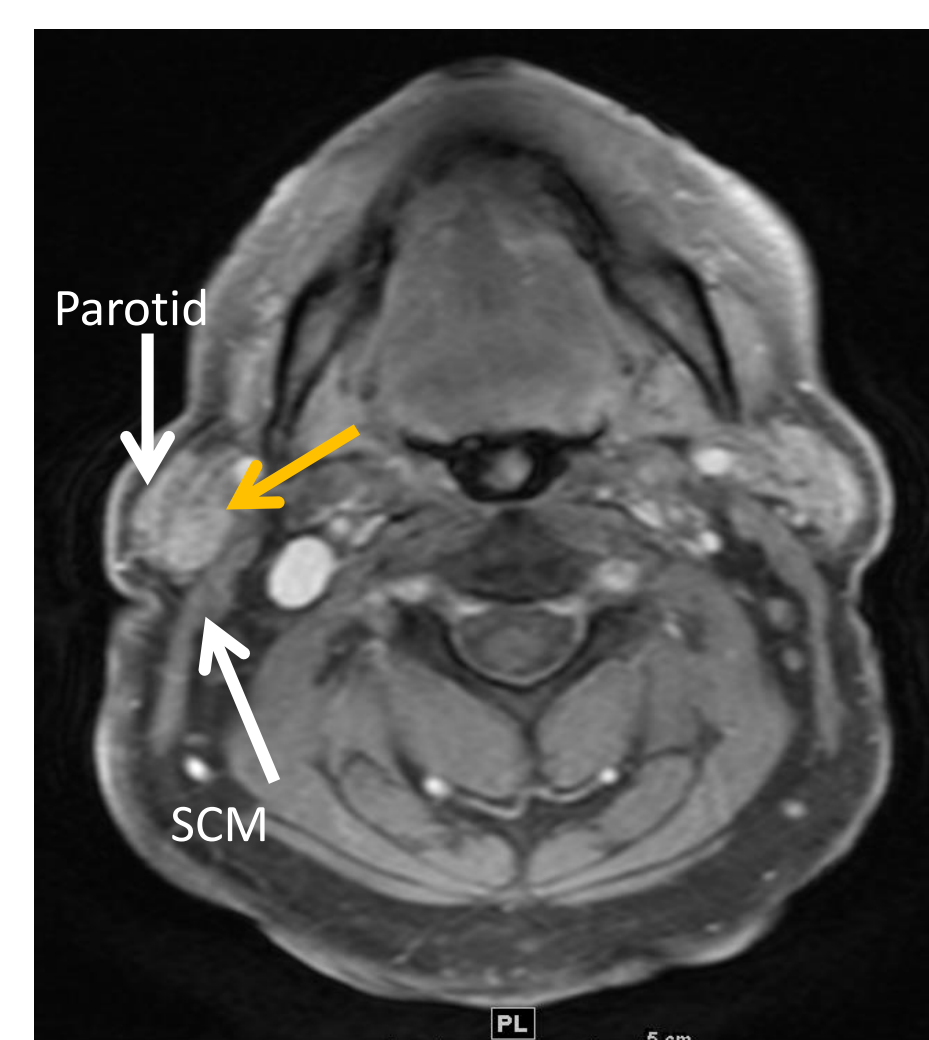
T1 MRI right parotid lesion
